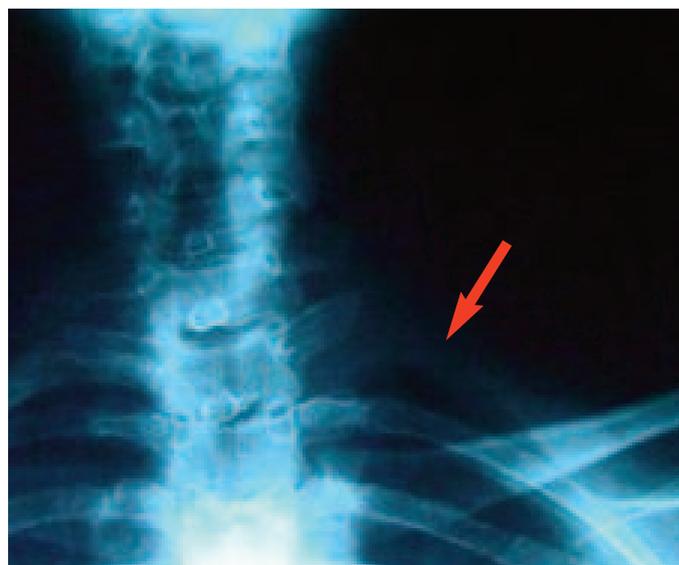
Cervical AP x-ray view (arrow) of the same patient following operation.
